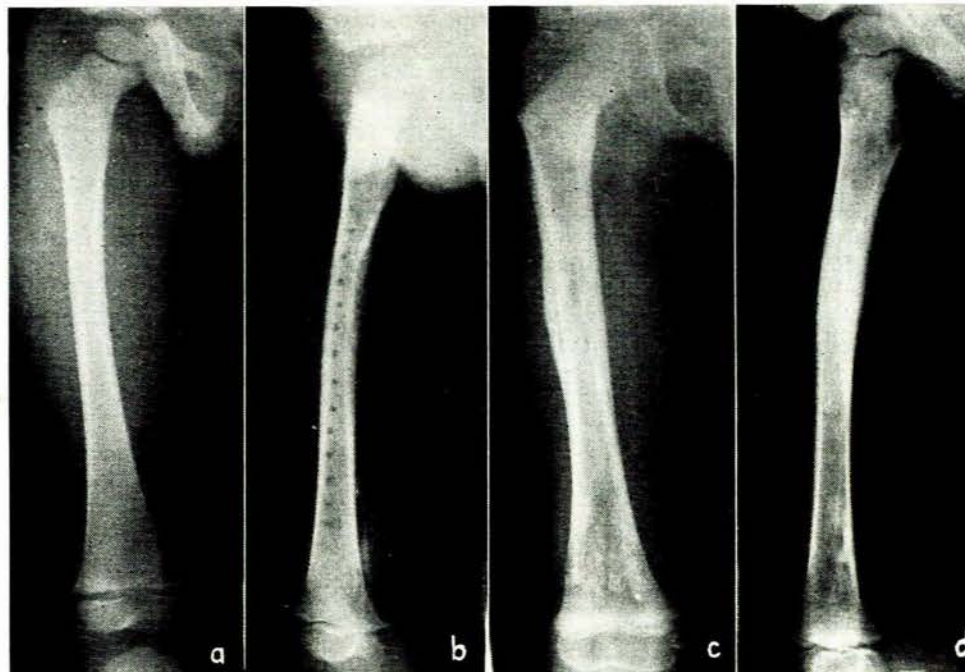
X-ray photo of right femur (case 2). (a) On admission. Note soft tissue swelling and oedema of right thigh. (b) 2 weeks later. Cortical erosion and destruction seen involving the entire shaft with periosteal reaction of similar extent. Drill holes are clearly visible. Also note extensive soft-tissue swelling persisting. (c) 5 months after admission. No bone erosion detectable with further consolidation of periosteal reaction. (d) 9 months after admission. Progressive healing noted with adequate new-bone formation.
